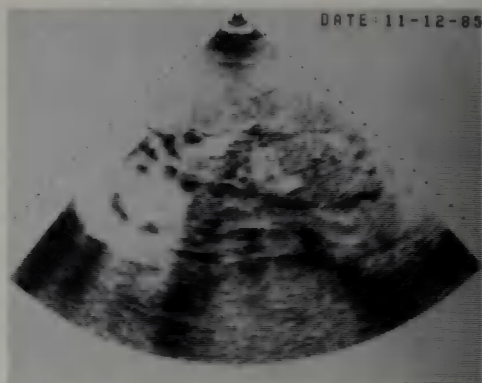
Ultrasonography. Note the anterior placenta.
